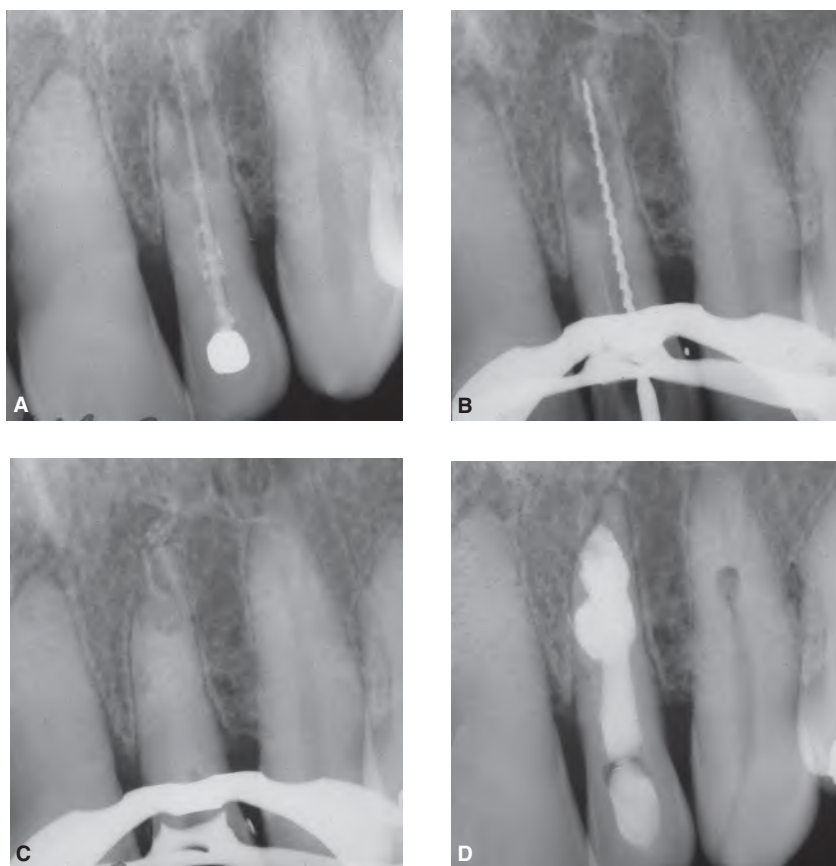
A. Radiograph showing a poorly sealed lateral incisor with a gutta-percha cone floating in the canal. An extensive internal resorption perforates the root in apical and mesial areas. B. In relatively large and straight canals, single gutta-percha cones can be removed with one H-file in one motion. C. The root canal was medicated with calcium hydroxide for three months. D. Postoperative radiograph after root canal filling demonstrating excellent repair and formation of a new periodontal ligament in the perforated areas.
